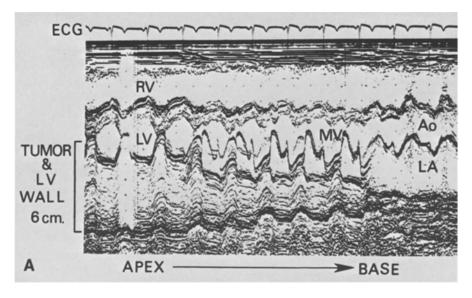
Echocardiography in a case of melanoma metastatic to the left ventricle. A Dense mobile echos within the left ventricle in systole represent metastatic tumor. B Systolic stop frame from a two-dimensional echocardiogram, apex four-chamber view. The metastatic tumor mass is seen within the left ventricle. The apex of the heart is at the top of the figure, the base at the bottom. LA, left atrium. MV, mitral valve, RA, right atrium, S and SEP, septum, T, tumor. (Reproduced with permission from [222], courtesy of author and publisher).
